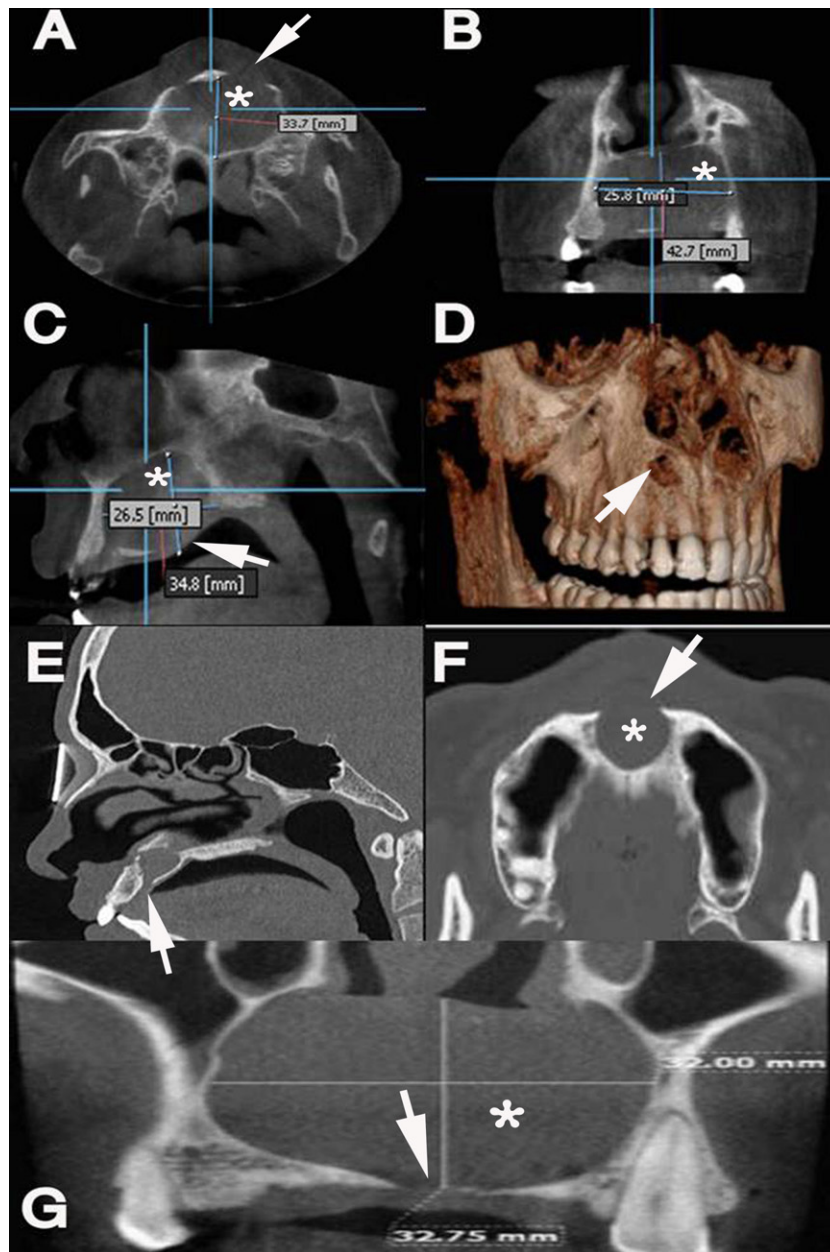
Nasopalatine cyst. *CBCT*: A–D (axial, coronal, sagittal and 3D images, respectively). *MDCT*: E–G (sagittal oblique MIP, axial, and magnified coronal MIP images, respectively). Both modalities showed round radiolucency with well-defined borders (*asterisk*), and both cortical plate defect (*arrows*). Both were identical in detection of location, internal structures, as well as cortical defect, however regarding dimensions MDCT overestimated the lesion height by 3 mm and CBCT overestimated it by 1 mm. MDCT underestimated the lesion width by 2.2 mm, and CBCT underestimated it by 0.5 mm.
